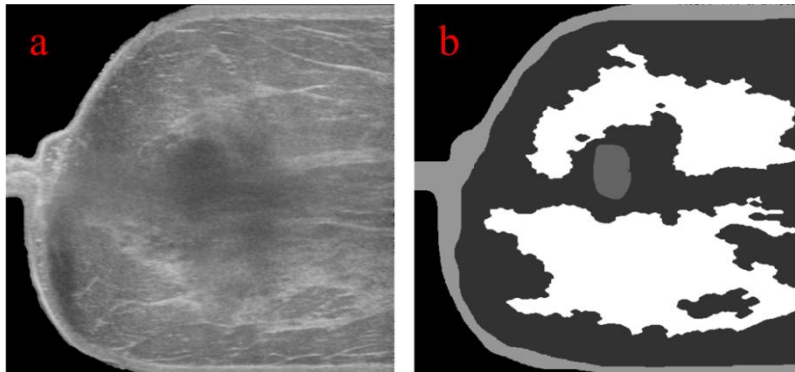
(a) The raw breast ultrasound image; (b) The annotated image where different tissues are marked with different grayscale values.
